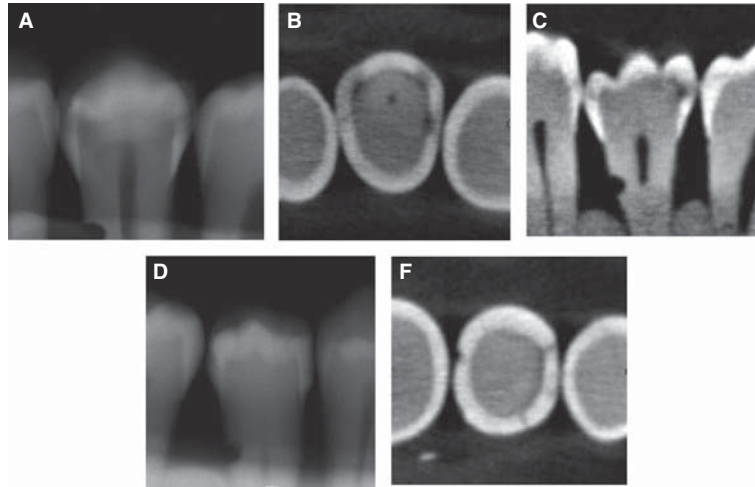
(A) bitewing-like radiograph of extracted premolar with deep lesions in both approximal surfaces; lesions scored as cavitated, (B, C) axial and sagittal CBCT sections of the same tooth showing the deepest demineralized area; lesions scored as non-cavitated. The lesion was clinically not cavitated. (D) bitewing-like radiograph of extracted premolar with shallow lesions in both approximal surfaces; lesions scored as non-cavitated, (E, F) axial and sagittal CBCT sections of the same tooth displaying cavitation in the left surface. This lesion was clinically cavitated.
